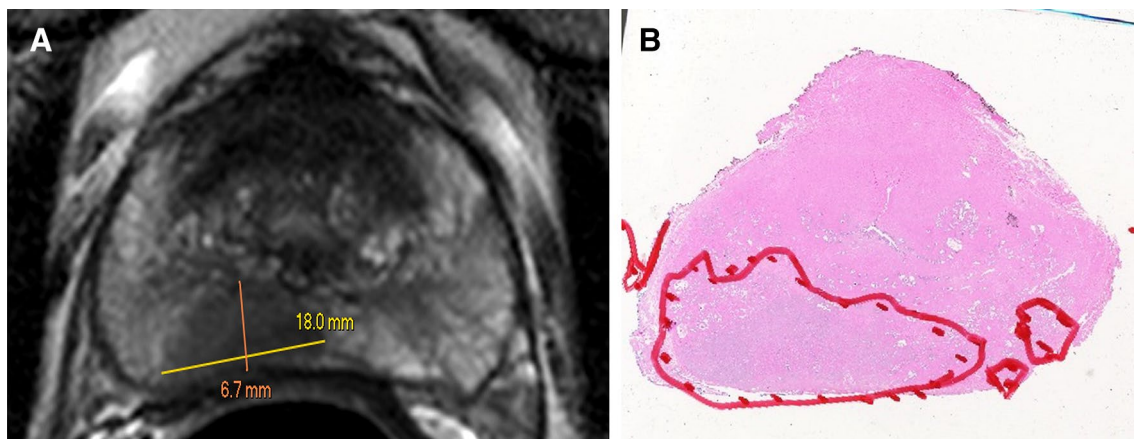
57 y/o male with PSA 11.47 ng/ml, Gleason 4+4 on biopsy, NIH MRI score=high, and radical prostatectomy on 6/14/2013. On pathology, the patient had Gleason 4+4, positive margins. Index
